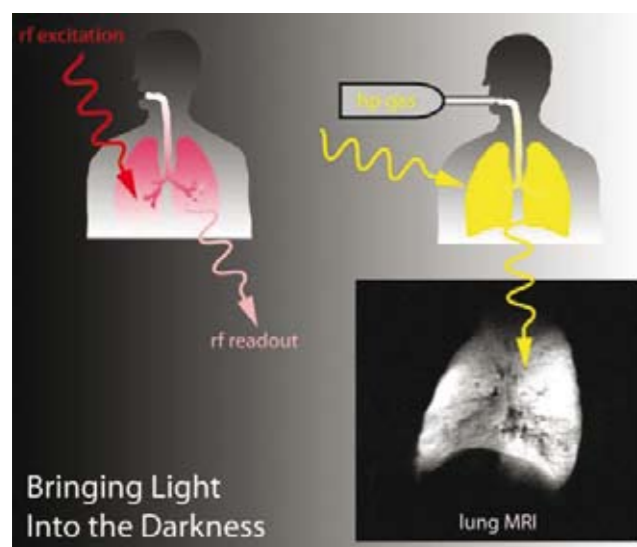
Following radio frequency (rf) excitation, the signal that is detected in conventional MRI is very weak and requires a high density of the nuclear spins. Imaging of void spaces can be realized by using hyperpolarized (hp) noble gases that benefit from a much higher detectable magnetization. In this example, helium imaging of the lung was one of the early applications of hp gases in biomedical studies. (Lung MRI reproduced from *Magn. Res. Med* 1996; 36: 192–196 with permission of John Wiley & Sons, Inc.)
